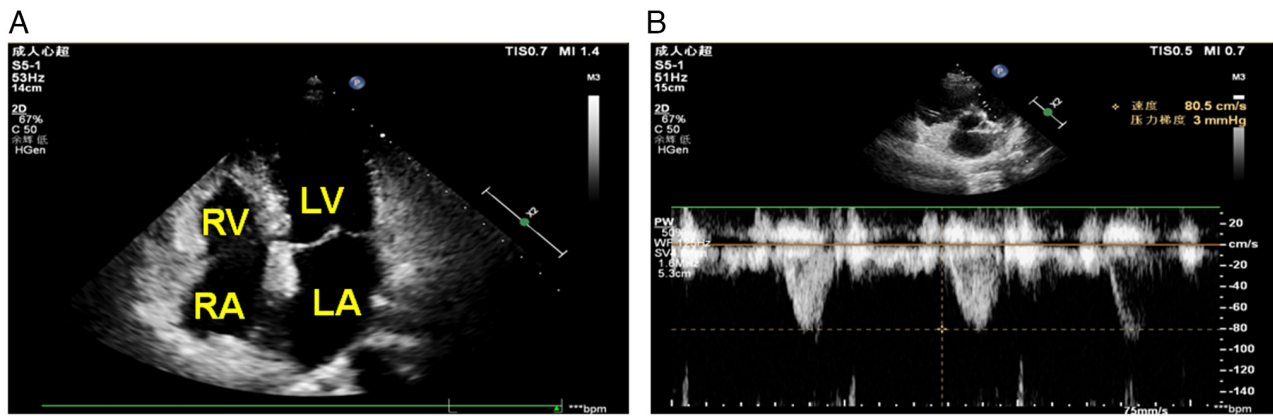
Four-chamber view by TDI. (A) Standard four-chamber section from the apical view. (B) Measurement of pulmonary artery blood flow in sections along the parasternal short axis. LV, left ventricle; LA, left atrium; RV, right ventricle; RA, right atrium; TDI, tissue Doppler image.
